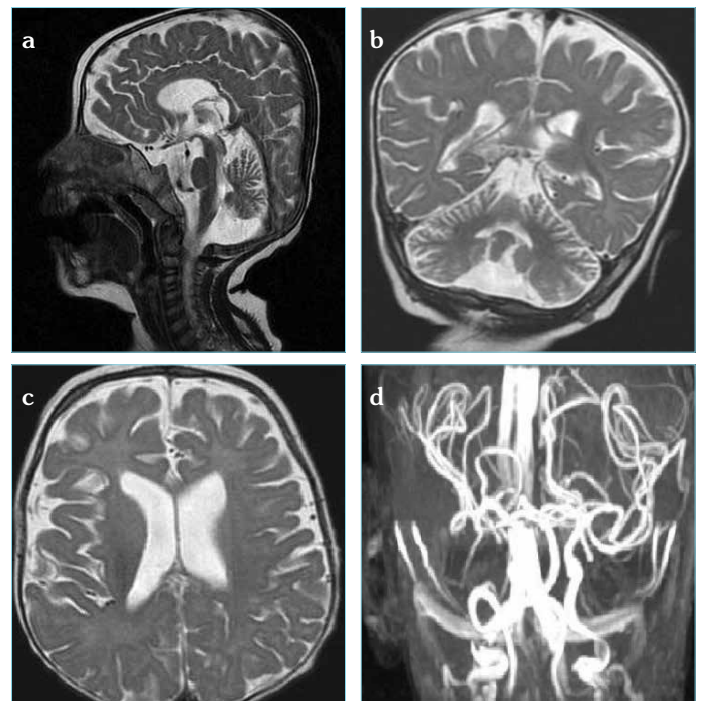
a-d. Sagittal (a) and coronal (b) and axial (c) T2W images of MRI show diffuse cerebral and cerebellar atrophy and MRA (d) image shows severe intracranial and extracranial vascular tortuosity in both middle cerebral and vertebrobasilar arteries
